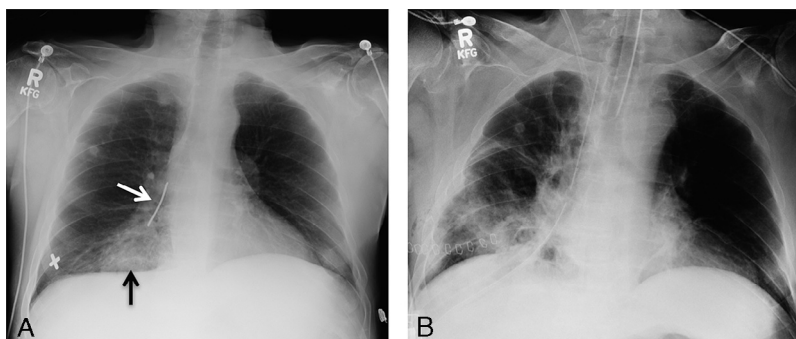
Initial portable chest radiograph (A) shows the metallic nail projecting over the right hilum (white arrow). The X in the right lower chest marks the entrance wound on the skin. Diffuse airspace opacification in the right cardiophrenic angle (black arrow) suggests lung contusion or hemorrhage. The follow-up portable chest radiograph (B), obtained after the surgery, shows absence of the nail in the right lung, right lower chest wall skin staples, a right-sided chest tube, and an endotracheal tube. Patchy opacities are seen in the right lung, suggesting contusion, hemorrhage, and linear atelectasis.
